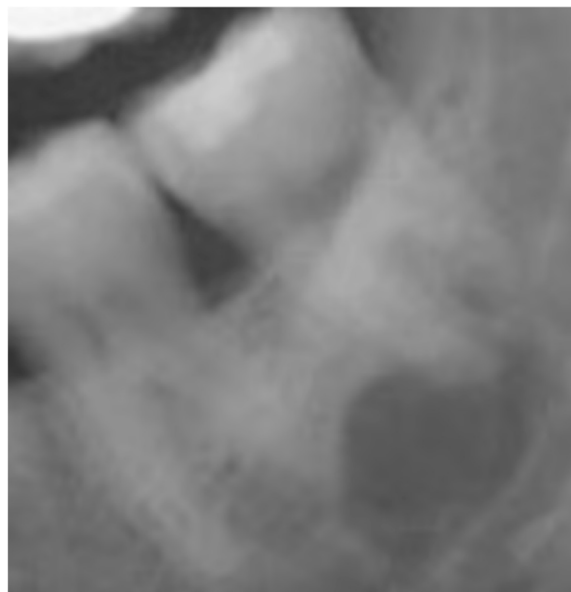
Periapical film showing a circumscribed radiolucency extending to the inferior alveolar nerve canal and involving the apical quarter of the mandibular left first and second molars, including the apices.
